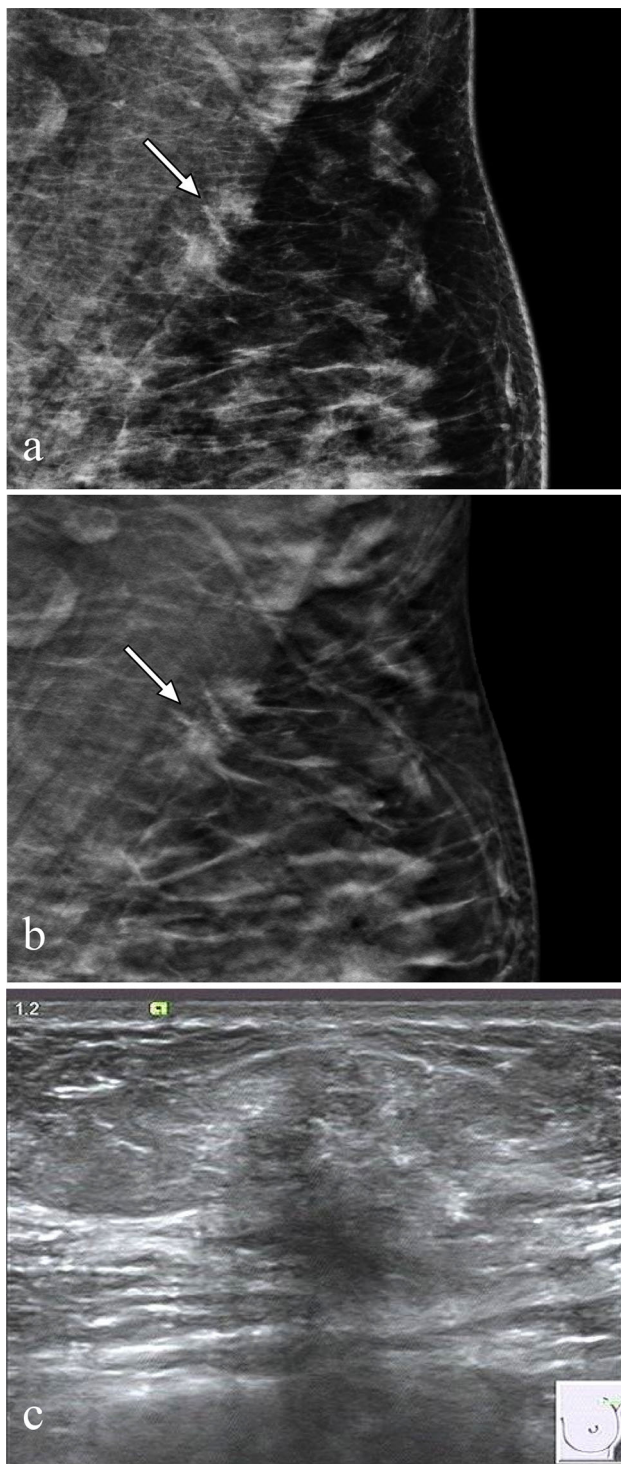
Mediolateral oblique and ultrasonography images in a 43-year-old woman with ductal carcinoma in situ in the *left* breast. a DM image. b DBT image. c US image. The spiculated mass margins are better shown in b than in a. US c showed a typically malignant findings
